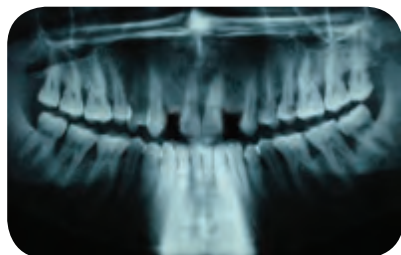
Orthopantomogram showing horizontal and vertical bone loss.
